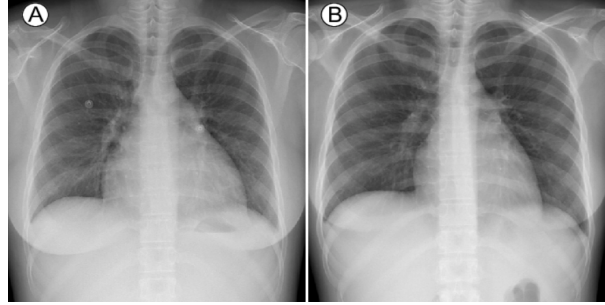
(A) A chest radiograph taken on admission revealed mild cardiomegaly and pulmonary congestion. (B) After methylprednisolone pulse therapy, chest radiography showed that the heart was of normal size and the lung parenchyma of normal appearance [7].
